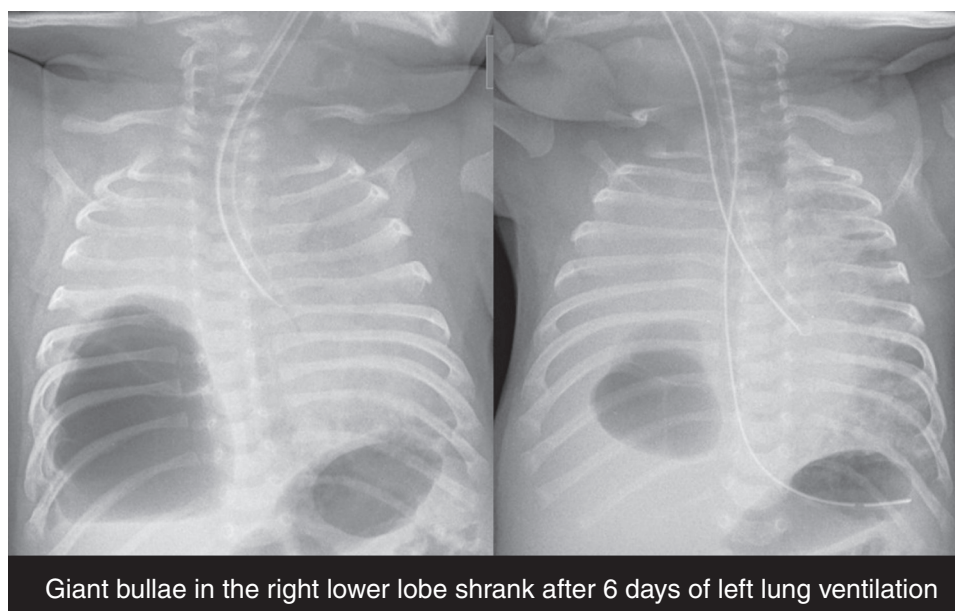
Chest X-ray showing left mainstem bronchial intubation with an endotracheal tube immediately after (left panel) bronchial placement and 6 days later (right panel). The right lung bullae had clearly shrunk over time allowing resumption of bilateral ventilation.
